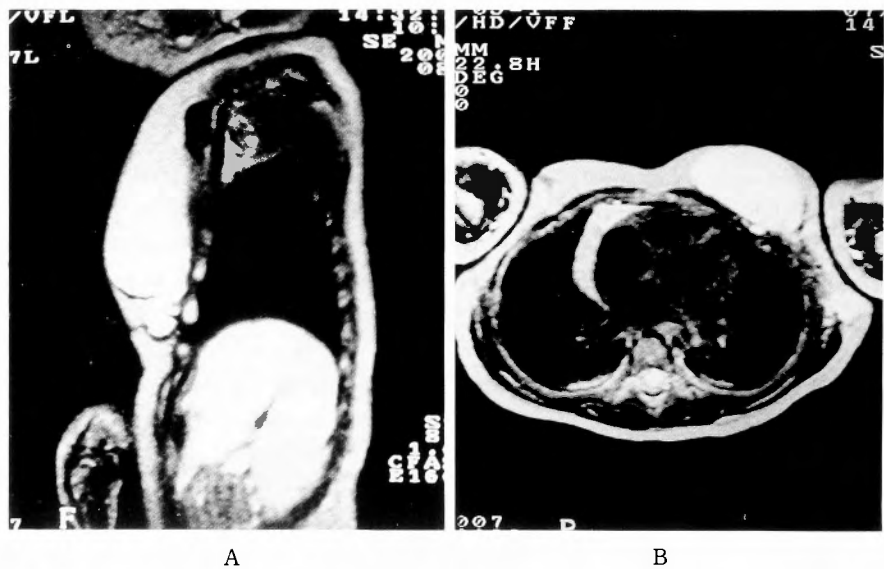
MRI demonstrating multicystic tumor of the breast. A: sagittal section, B: transverse section.
